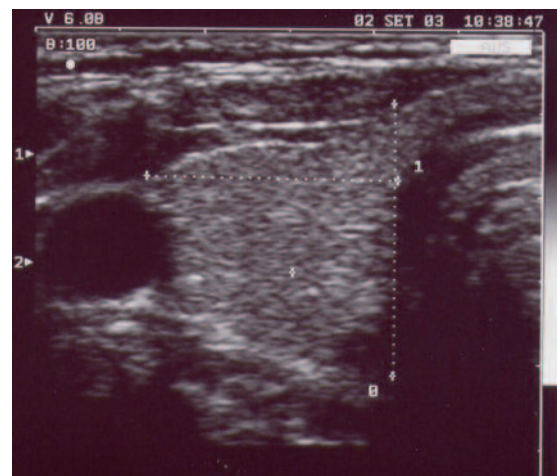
Normal thyroid gland: the transverse sonogram of the right lobe made with high resolution (10 MHz) small parts transducer shows a triangular shape and an homogeneous parenchyma having more echogenicity on respect to the near neck muscles (sternothyroid, sternohyoid, omohyoid and sternocleidomastoid muscles). Tracheal air shadow is clearly identified on the right and the common carotid artery on the left.
